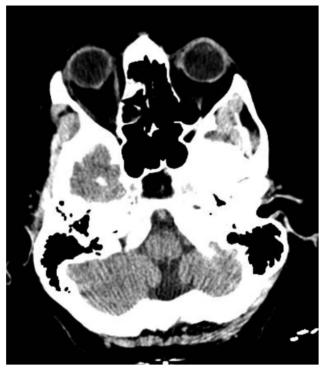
Initial non-contrast head CT, prior to t-PA.
